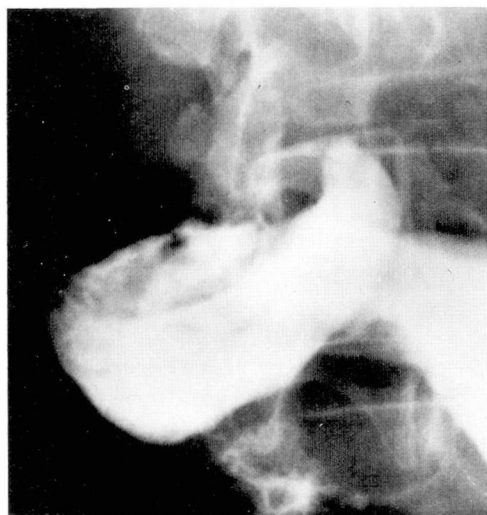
A, Case 2. Roentgenogram shows a large duodenal bulb with a filling defect in its inferior surface. Descending duodenum is irregularly distorted, suggesting possible tumor invasion.
